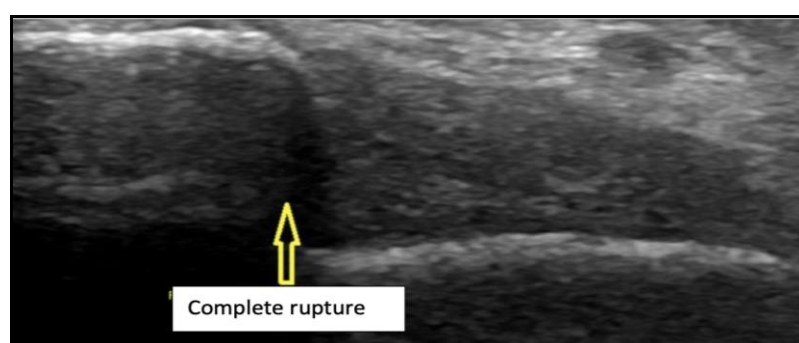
Ultrasound image of a complete rupture of the anterior bundle of the LCL
